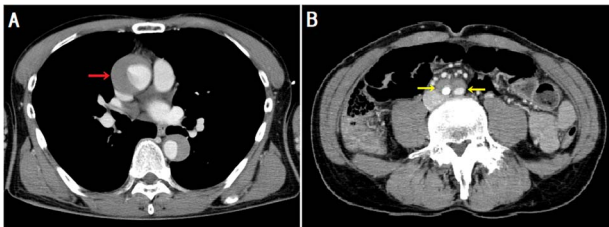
Enhanced computed tomography showing a type A aortic dissection. The dissection extended from the ascending aorta (A, arrow) to the bilateral common iliac artery (B, arrows). The false lumen was completely thrombosed.
